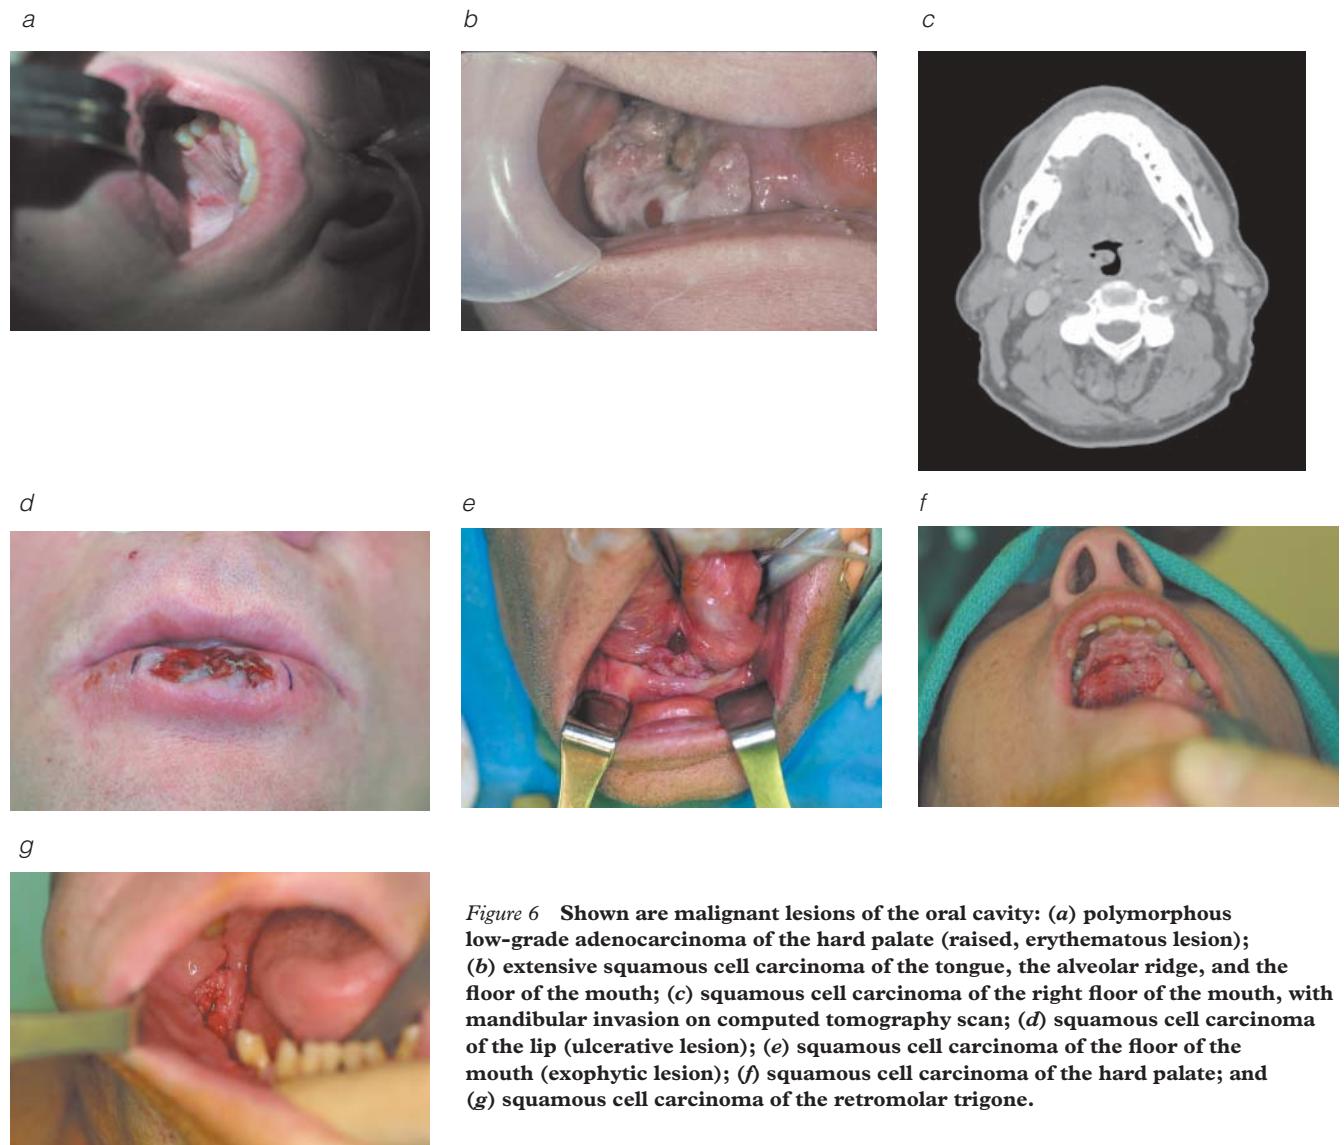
Shown are malignant lesions of the oral cavity: (a) polymorphous low-grade adenocarcinoma of the hard palate (raised, erythematous lesion); (b) extensive squamous cell carcinoma of the tongue, the alveolar ridge, and the floor of the mouth; (c) squamous cell carcinoma of the right floor of the mouth, with mandibular invasion on computed tomography scan; (d) squamous cell carcinoma of the lip (ulcerative lesion); (e) squamous cell carcinoma of the floor of the mouth (exophytic lesion); (f) squamous cell carcinoma of the hard palate; and (g) squamous cell carcinoma of the retromolar trigone.
